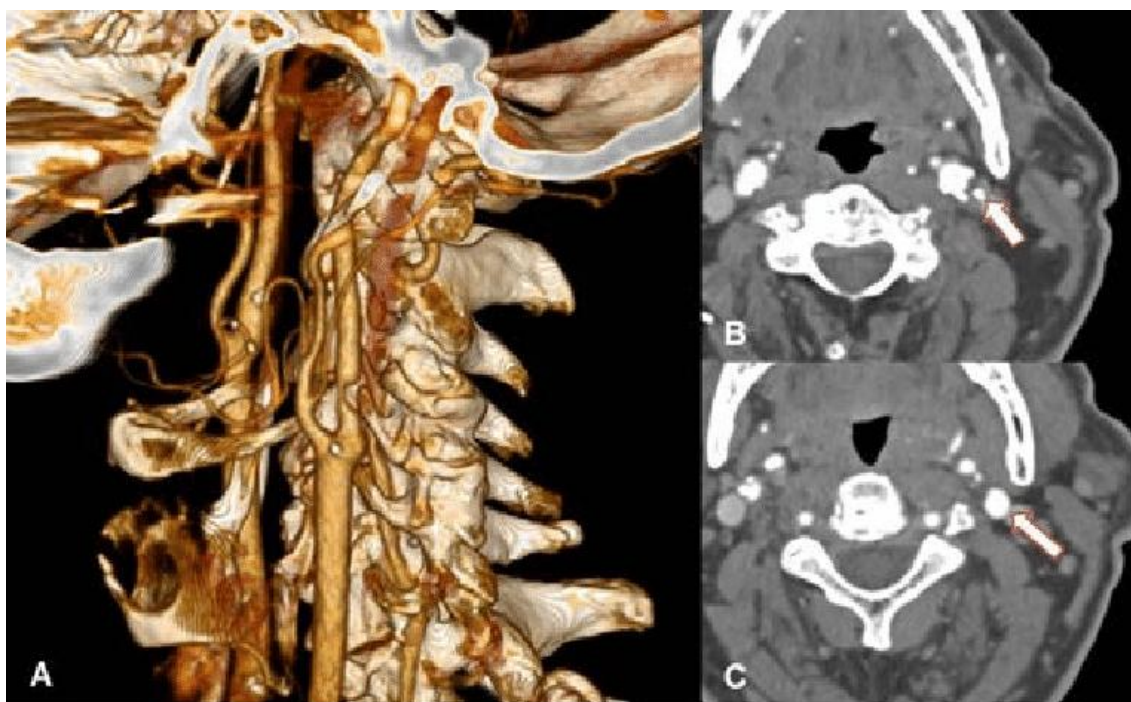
NASCET method for measuring carotid artery stenosis. Volume rendered CTA axial (A) and MPR images (B and C). The volume rendered post-processed CTA image (A) show the anatomic sites of measurement in the carotid artery for calculating percent stenosis for the NASCET method. It was calculated as the ratio between the residual luminal surface at the stenosis (B) and the surface of the distal normal lumen where there is no stenosis (C)¹⁵⁷
